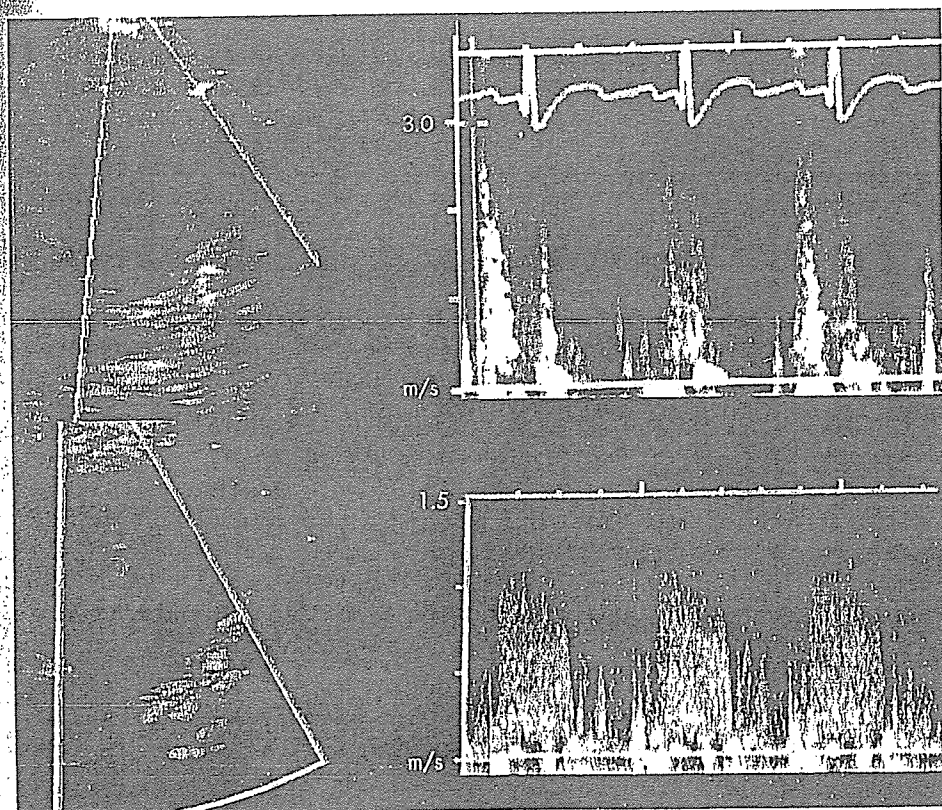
Pressure gradient at localised stenosis estimated by Doppler echocardiography. (Top) Echocardiogram before coronary artery bypass grafting (CABG) at 10 years. The velocity at the localised stenosis was 2.8 m/s. (Bottom) Echocardiogram after CABG. The velocity at the localised stenosis was 1.0 m/s.
